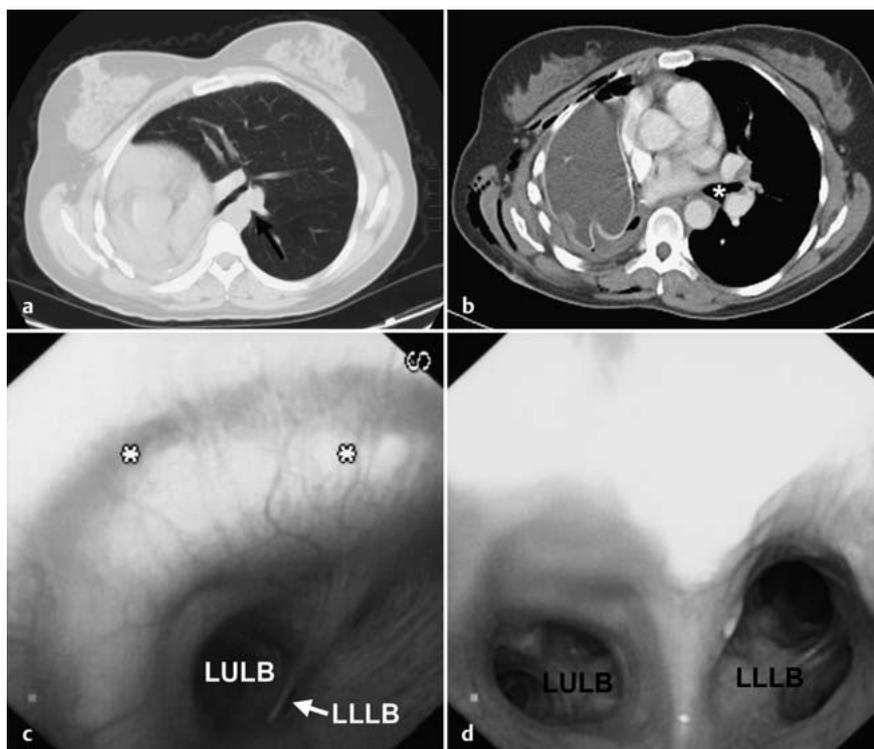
a to d Pre- (a) and postoperative (b) computed tomography of the chest, and intraoperative bronchoscopy before (c) and after (d) insertion of the saline implant.
